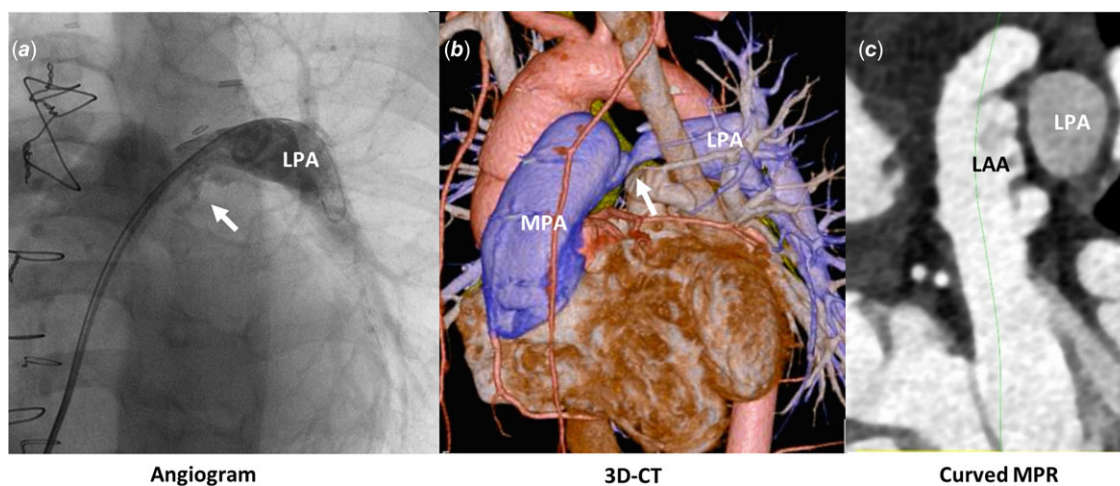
(a) A tear can be seen in the middle of the stenotic area at the underside of the left pulmonary artery with minimal contrast extravasation. (b) The distance between the LAA and the narrowest part of the LPA was small. (c) The proximal LAA was in contact with the LPA, and the connective tissue thickness between them was $< 1\text{ mm}$. 3D-CT: three-dimensional CT; LAA = left atrial appendage; LPA = left pulmonary artery; MPR = multiplanar reconstruction.
